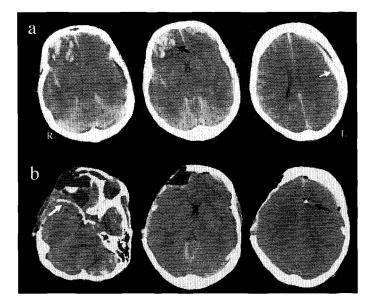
a Preoperative CT scan. *White arrow*: acute subdural hematoma. *Black arrow*: contusional hematoma. b Postoperative CT scan. *White arrow*: catheter for CSF drainage. *Black arrow*: ICP sensor
